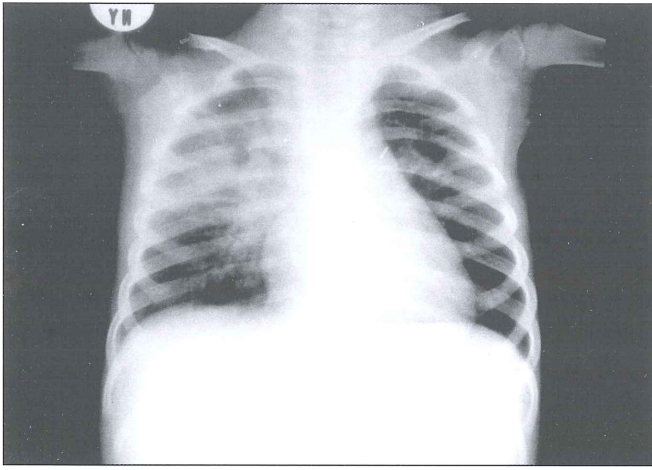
Plain chest radiograph shows right upper lobe consolidation with prominent horizontal fissure. There is linear density on the left hilum due to the patent ductus arteriosus surgery.
